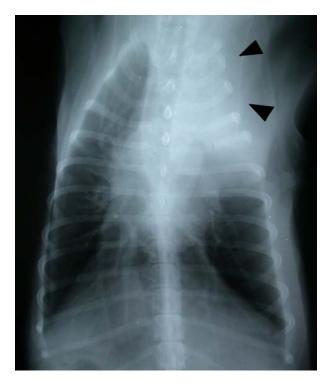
Ventro-dorsal and lateral (right recumbency) thoracic radiographs (seven days after surgery) showing: increased radiopacity of the cranial areas of the thorax – normal lobar radiopacity of the other lobes. The radiographic finding was indicative of a left fibrotorax
